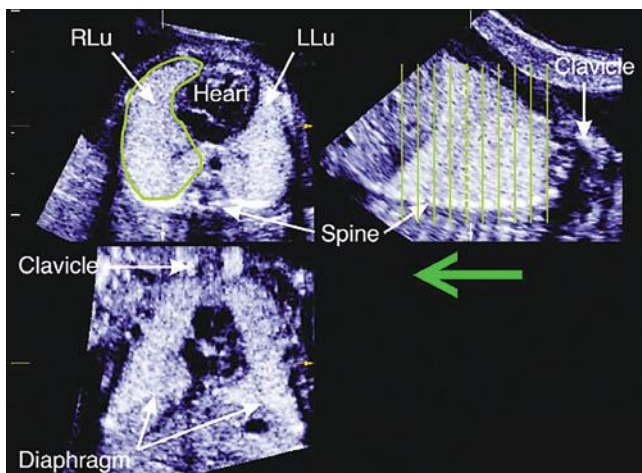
Three-dimensional ultrasound fetal lung measurements using the multiplanar technique. Note the image sequences (*green vertical lines*) used to obtain transverse views of the lung. The right lung (RLu) is outlined. Fetal lung volume is obtained by scrolling through the transverse plane (*green arrow*). LLu, left lung. (From Kalache KD, Espinoza J, Chaiworapongsa T, et al: Three-dimensional ultrasound fetal lung volume measurement: a systematic study comparing the multiplanar method with the rotational (VOCAL) technique. *Ultrasound Obstet Gynecol* 21;111, 2003.)
